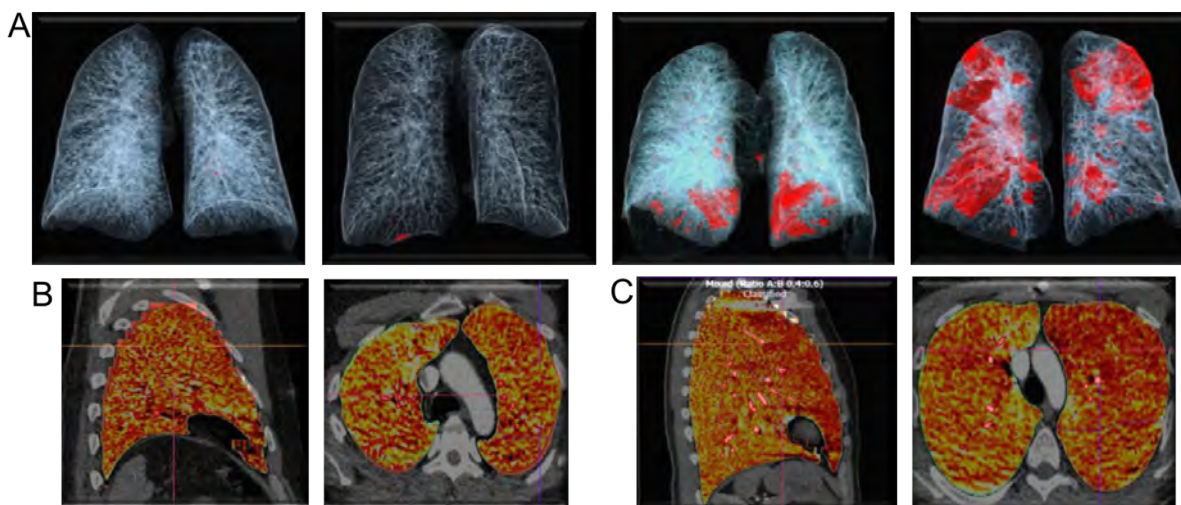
Prevalence of abnormal DECT finding by PET/MR imaging categories. (A) DECT images showing varying amount of lung opacities (in red). (B) Representative DECT perfusion images with homogenous distribution of contrast agent. (C) Representative DECT perfusion showing abnormal perfusion.
